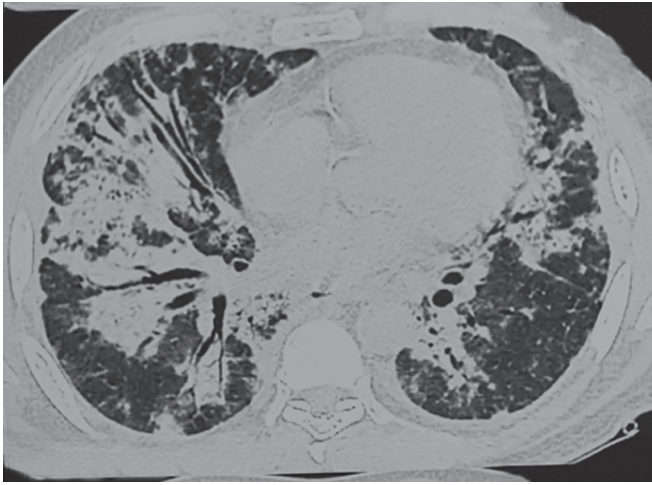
The HRCT chest showing bilateral patchy opacities with air bronchograms suggestive of organizing pneumonia
